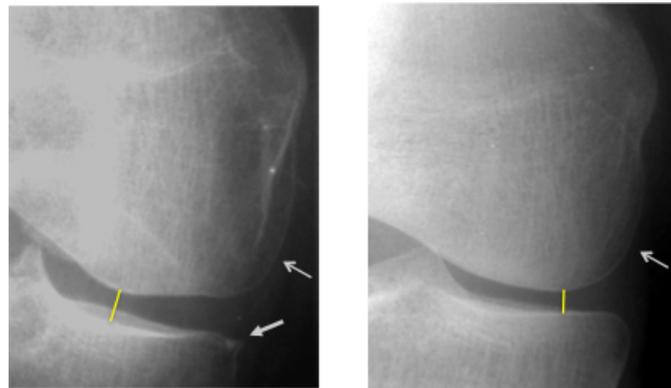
Pseudo-JSN. These are the same images as in Fig. 3. In this case the focus is on JSN. Note that the joint-space width (yellow line) in B is narrower than that in A, which is a knee with definitive OA. In absolute terms, however, the width in B is still within the range of normal, and without a prior image to confirm that this is true change, it cannot be assumed to be narrowed. If the bone protuberance along the margin of the femur (arrow) in B is actually an osteophyte, the probability of the apparent JSN being real would increase – and vice versa, of course. In this way, misdiagnoses in radiography can behave synergistically.
